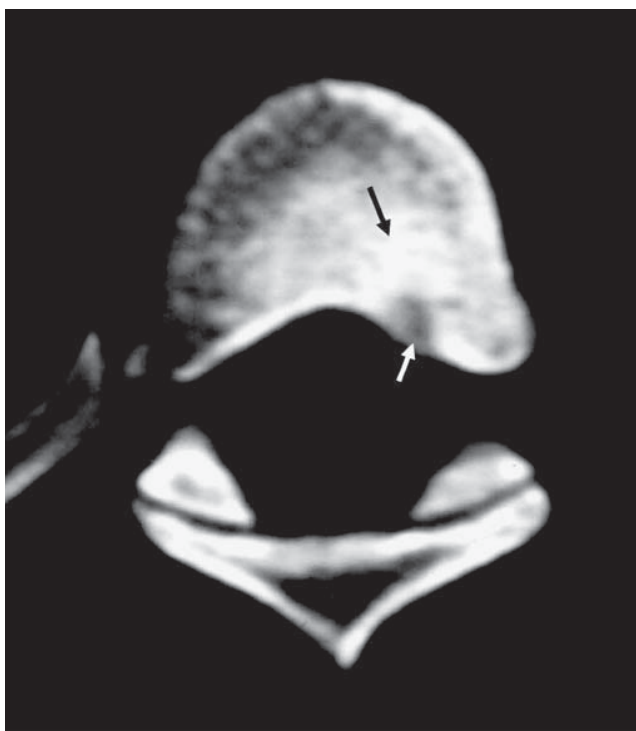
CT: 14 months post initial presentation
